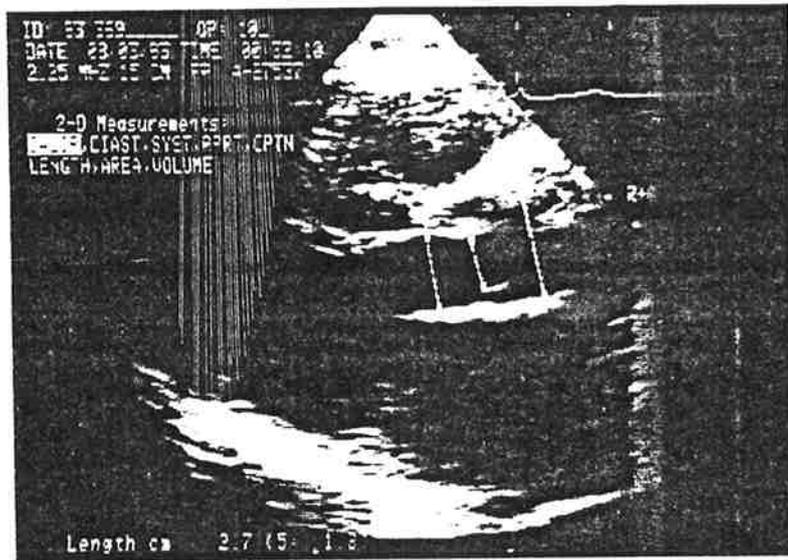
PARASTERNAL LONG AXIS VIEW OF THE LEFT VENTRICULAR OUTFLOW TRACT
